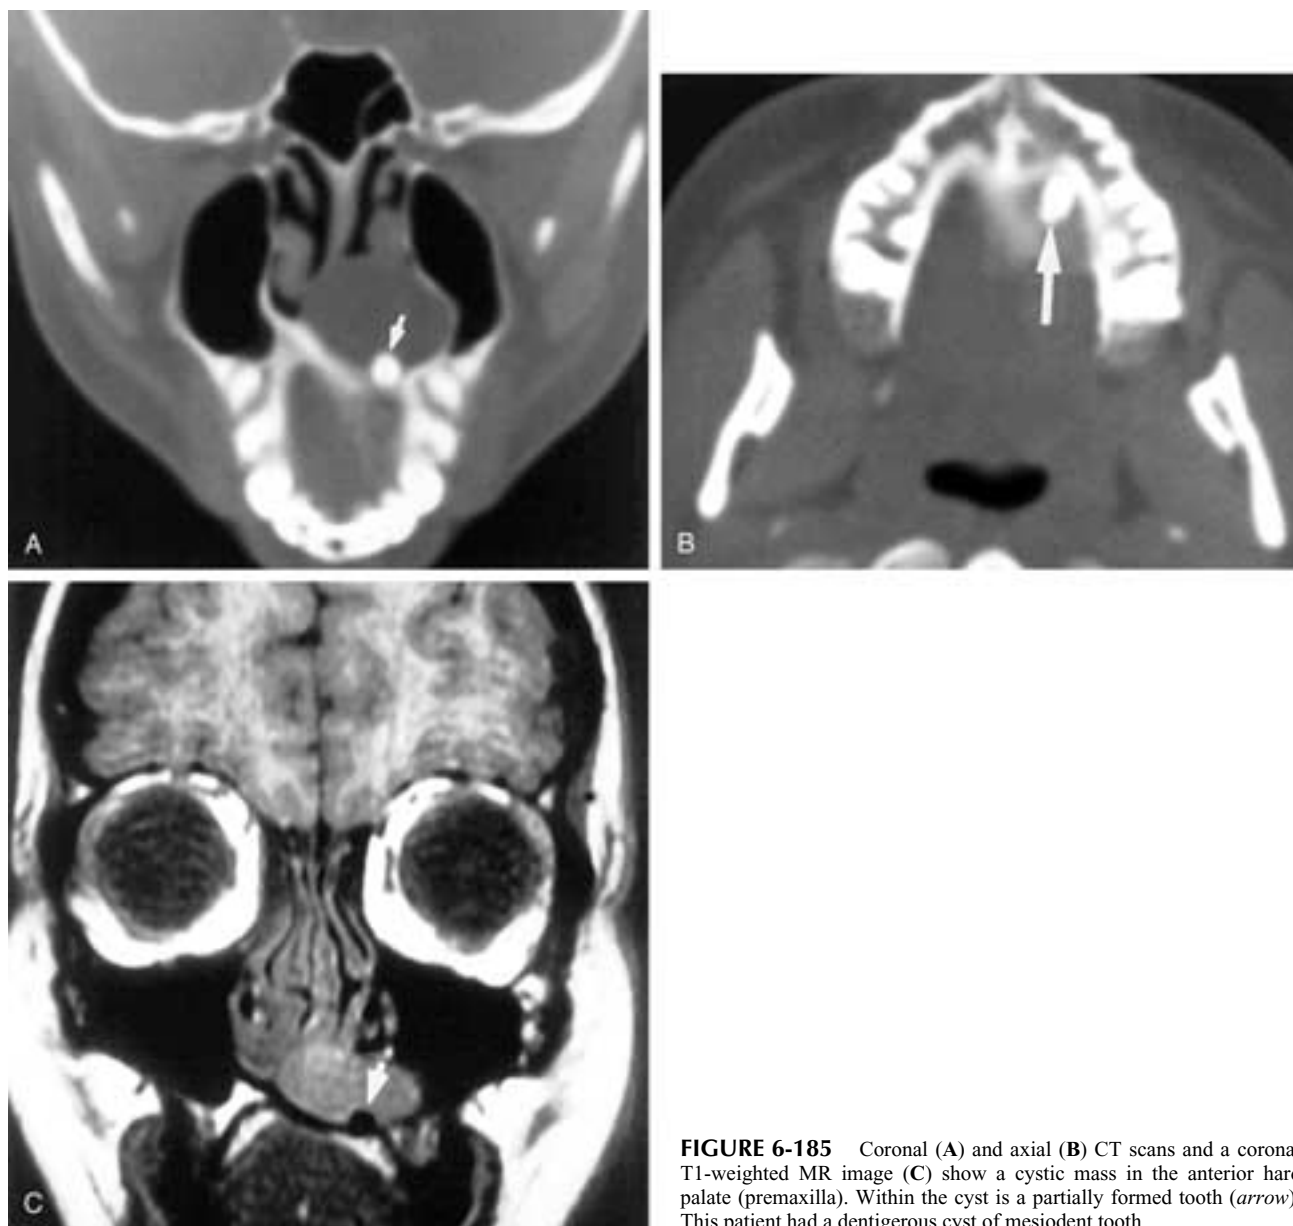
Coronal (A) and axial (B) CT scans and a coronal T1-weighted MR image (C) show a cystic mass in the anterior hard palate (premaxilla). Within the cyst is a partially formed tooth (arrow). This patient had a dentigerous cyst of mesiodent tooth.
